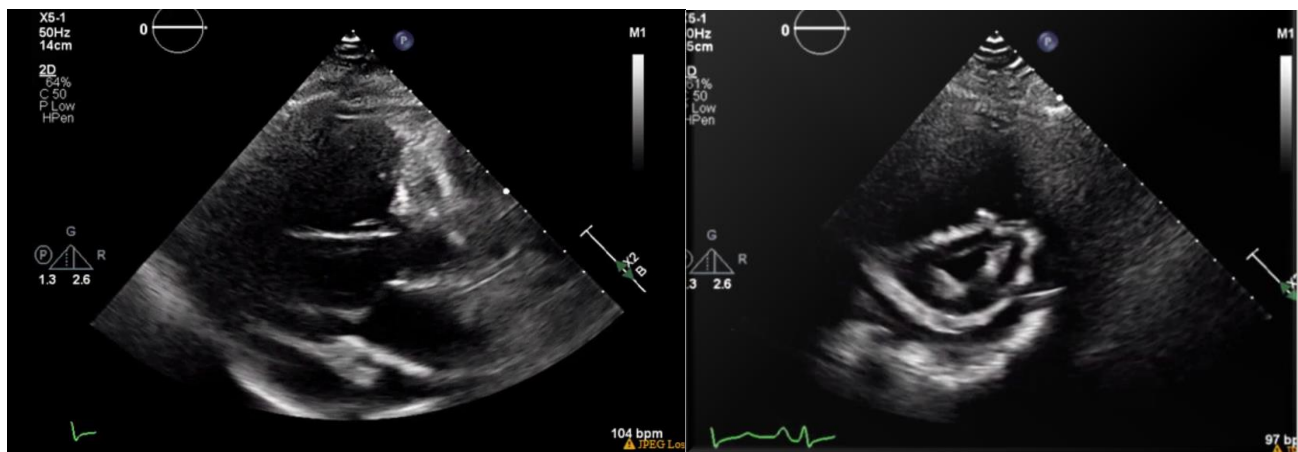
Pre-transplant transthoracic echocardiogram. Pre-transplant parasternal long axis and short axis views show a distended right ventricle and D-sign. Reported values: left ventricle ejection fraction 73%, left ventricle internal diameter during diastole 2.74 cm.
